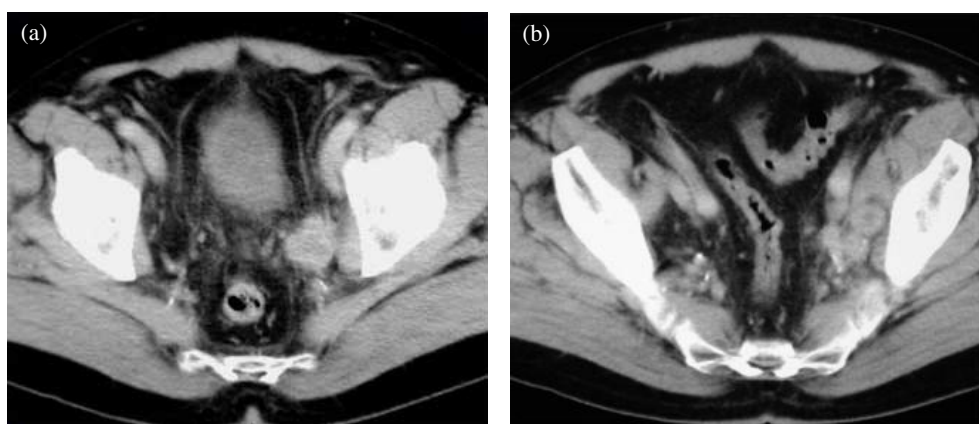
Prostate cancer. CT scan showing (a) left obturator nodal involvement and (b) left obturator and hypogastric nodal spread.
